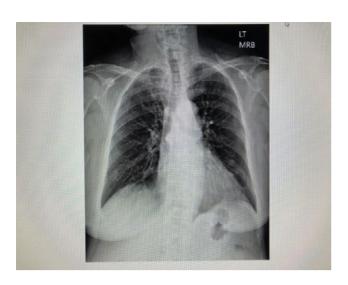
Chest radiograph 6 weeks after treatment with acyclovir. Successful treatment of acyclovir, as noted by clearing of consolidation in bilateral lung fields (Case 1).
